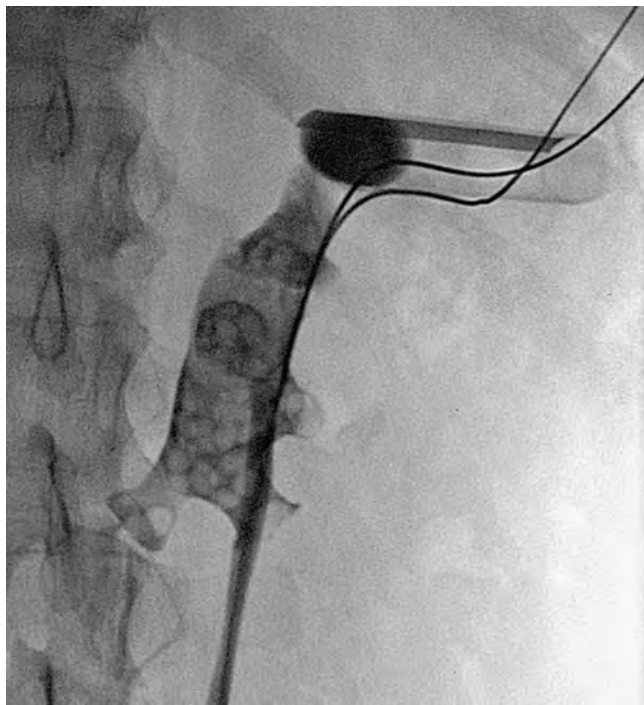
Percutaneous access sheath (radiolucent except for a radiopaque stripe) in upper pole of horseshoe kidney. Note medially directed lower pole calyx. Although not apparent from this radiograph, the access site is subcostal.
